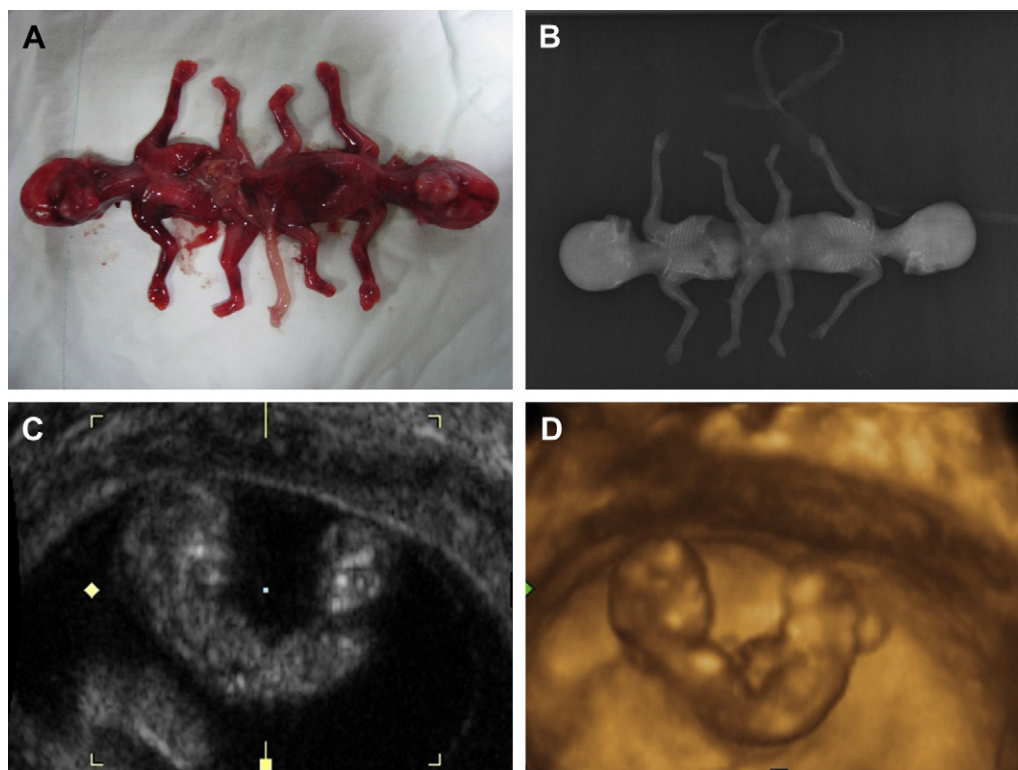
Case 1. (A) A case of ischiopagus delivered at 12 weeks of gestation. (B) Radiograph of ischiopagus. (C) Two-dimensional (2D) ultrasound of ischiopagus at 10 weeks of gestation. (D) 3D ultrasound of ischiopagus at 10 weeks of gestation.
